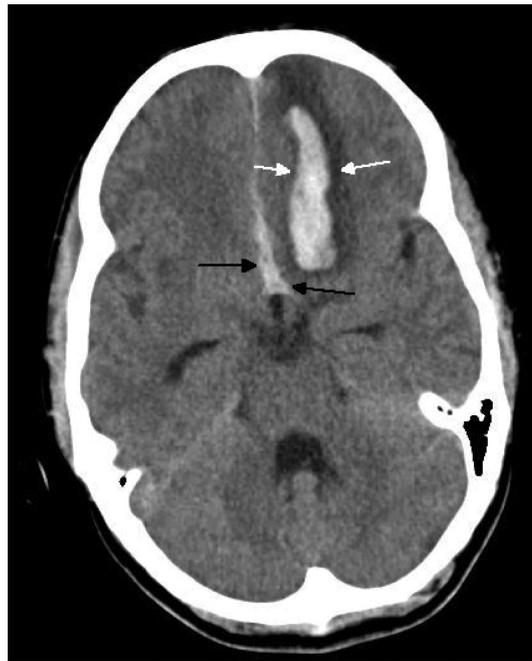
Axial plain CT scan of the brain showing a large left frontal intraparenchymal haemorrhage with perifocal oedema (white arrows). There are also associated subarachnoid haemorrhage (black arrows) and intraventricular haemorrhage
